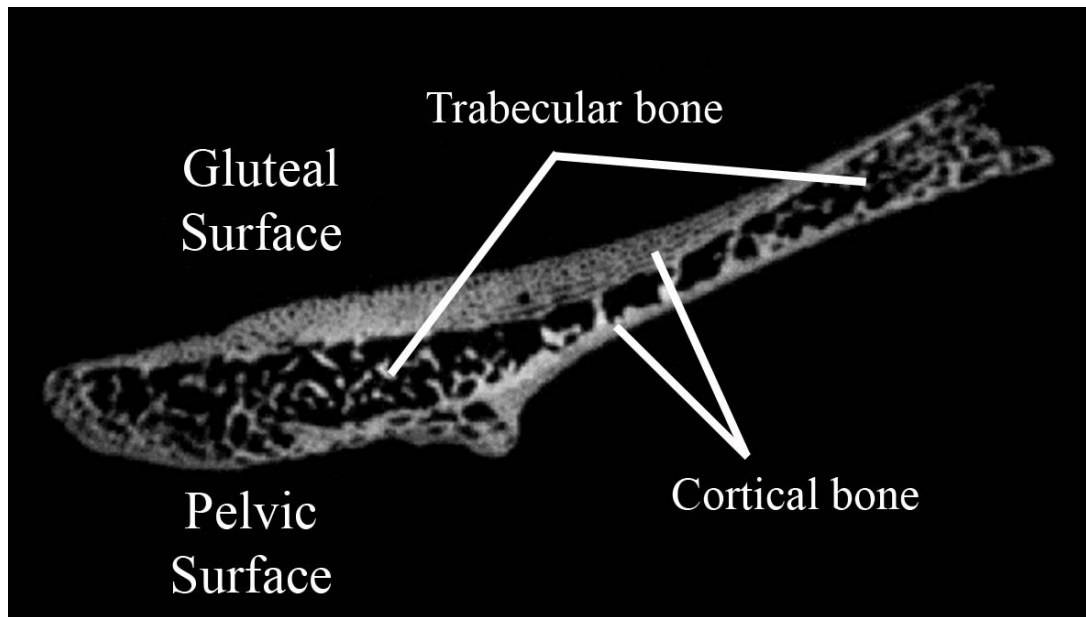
2D μ CT slice through a neonatal iliac blade in transverse plane.
